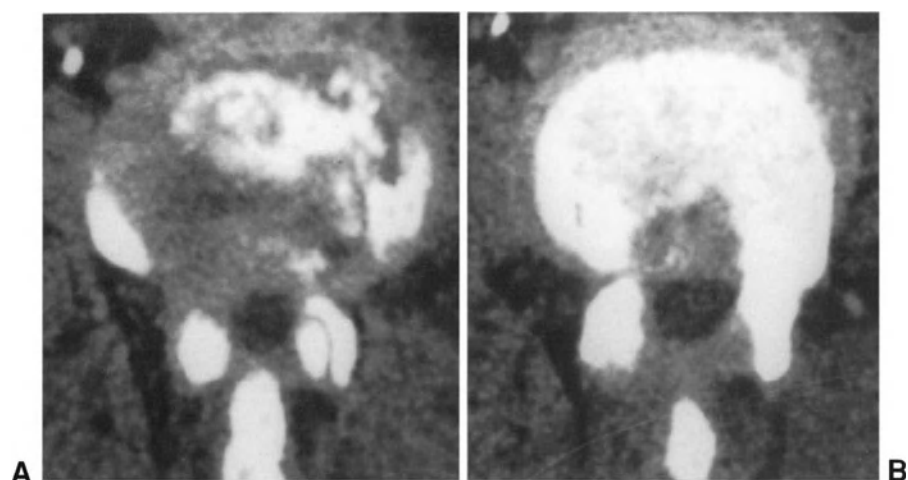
CT scans in a patient with spondylodiscitis following laminotomy and discectomy at L3-L4 level. The CT scans show a marked destruction of the L4 vertebral body, with diffusion of the infective process to the soft perivertebral tissues (A) and a large erosion of the posterior portion of L3 vertebral body (B).
